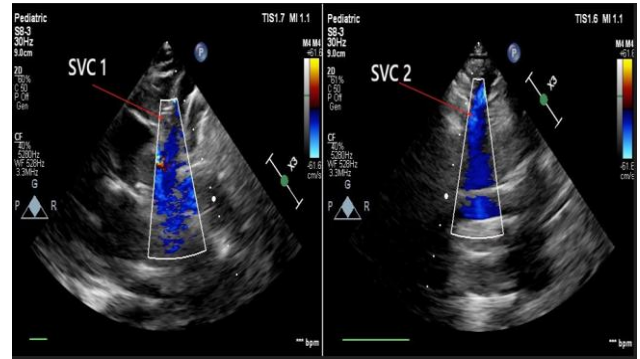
Transthoracic echocardiography (2D ECHO) showing bilateral superior vena cavae.
